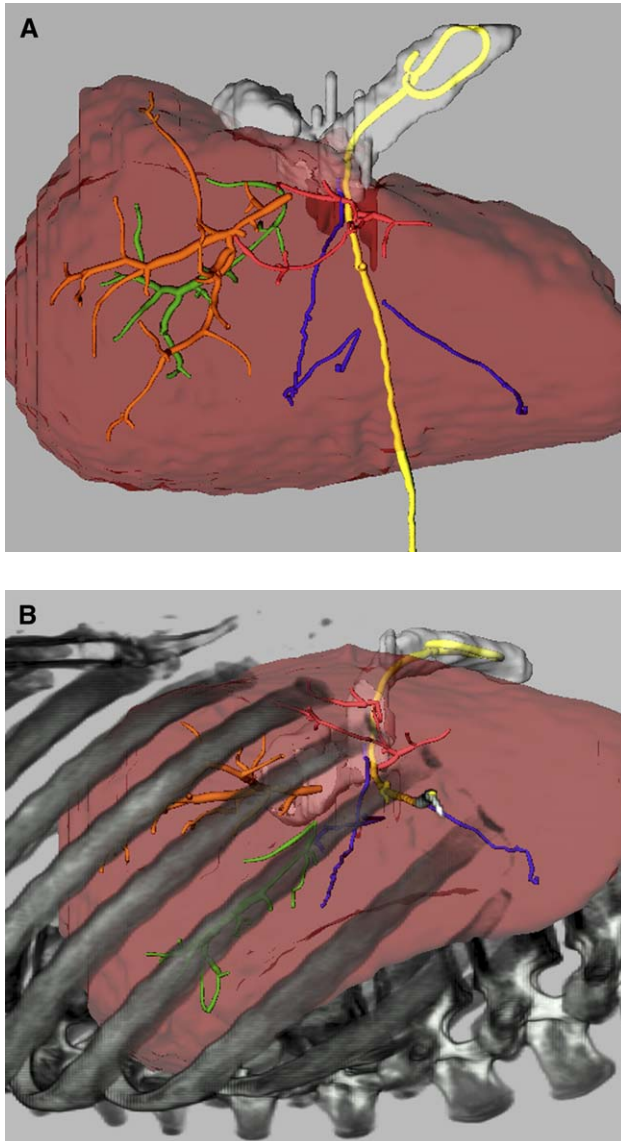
(A) Frontal three-dimensional CT cholangiogram of right lobe graft, percutaneous transhepatic cholangiocatheter (PTC, yellow) in intestinal loop (gray). Segmental ducts to segments 7 and 8 (green and gold) are dilated and not draining into the loop properly. (B) Lateral view of the same patient, now with rib cage overlay; this aids in percutaneous access to the upper right lobe ducts and decreases the number of passes through the graft parenchyma required for successful introduction of a second PTC catheter.
